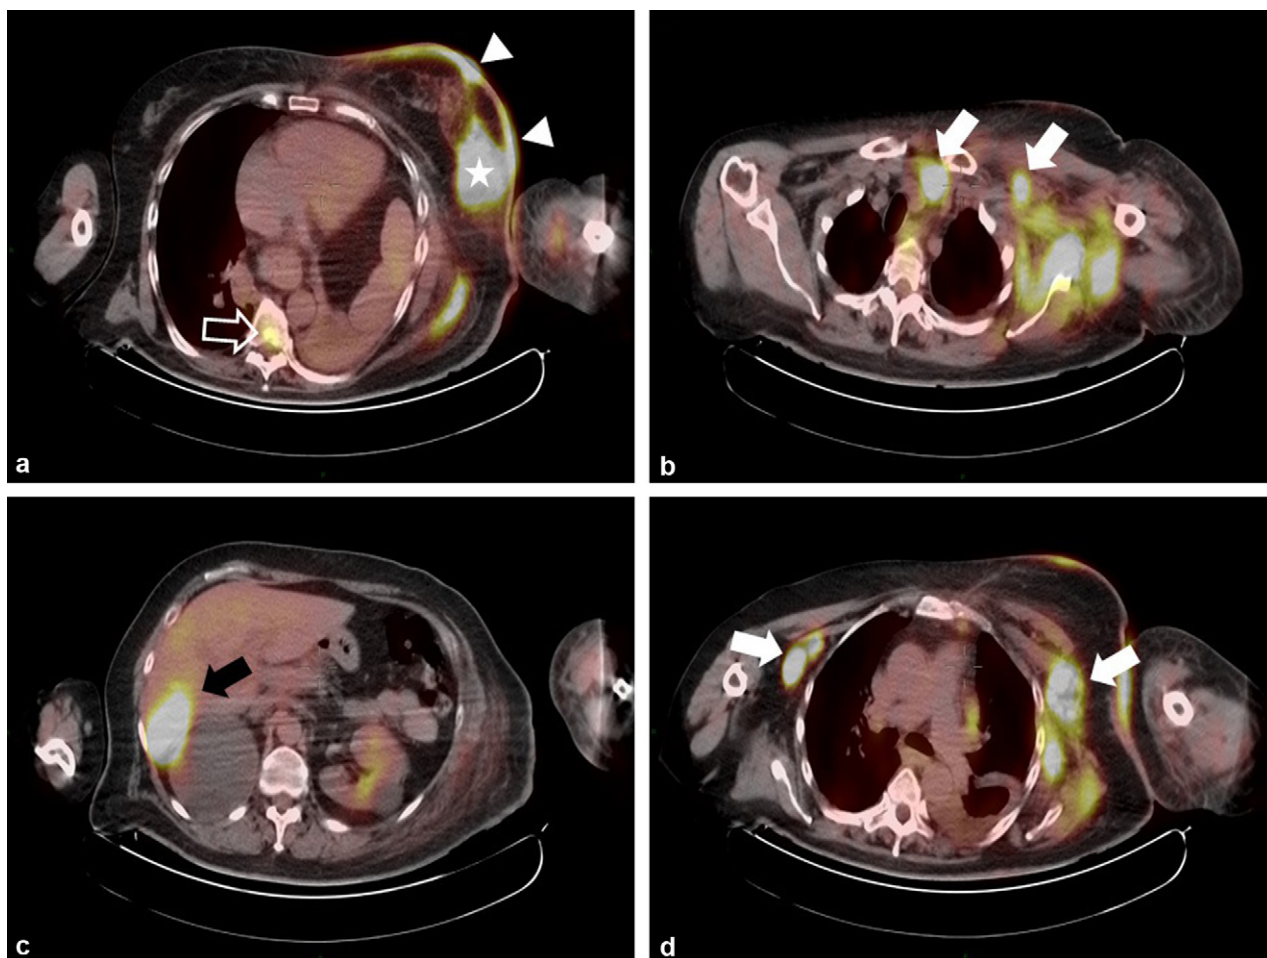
Staging of an infiltrating ductal carcinoma (SBR grade III, triple negative, with P53 mutation) of the left breast, clinically PEV 3 (a). Locally, the PET-CT with ^{18}F FDG shows the tumour (star) of the left breast and skin infiltration (arrow head). Regional staging shows bilateral axillary, left subclavicular and mediastinal adenopathies (arrow) (b, c, d). The PET-CT also shows hepatic (black arrow) and bone (hollow arrow) metastases.
